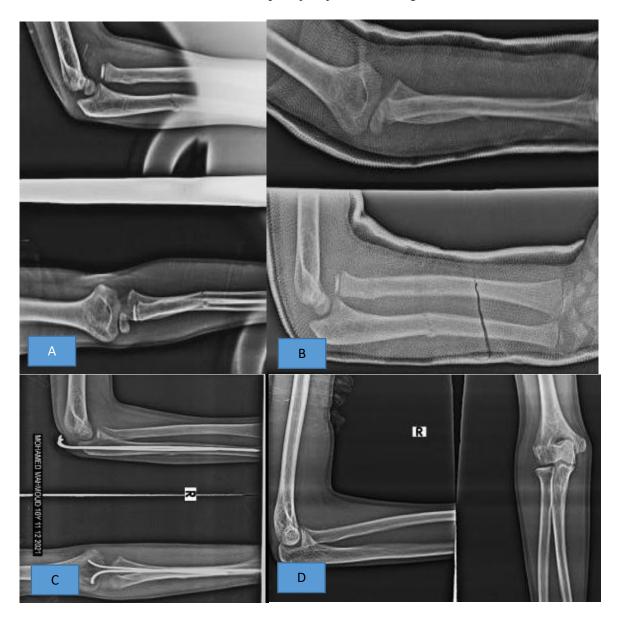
A: Ten years old boy with a Monteggia fracture dislocation was seen by a junior orthopedic surgeon, who missed the dislocated head radius. B: Follow-up x-ray showed a missed Monteggia fracture dislocation. C: The patient underwent closed reduction and percutaneous pinning with 2 K-wires. D: Follow-up X-ray after the ulnar fracture union and the extractions of the K-wires showed a well-reduced subacute Monteggia fracture.
